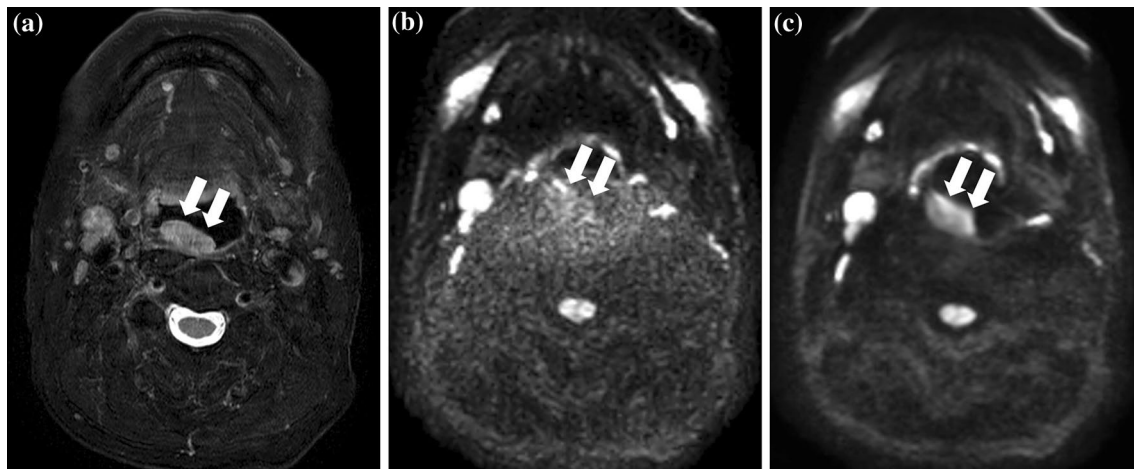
Representative patient with posterior wall oropharyngeal cancer. In fat-suppressed T2WI (a), a primary tumor lesion located mainly on the posterior wall of the oropharynx was observed as a high-signal-intensity mass (a: arrow). In DWI with conventional PI-based reconstruction (b), the depiction of the primary lesion was
